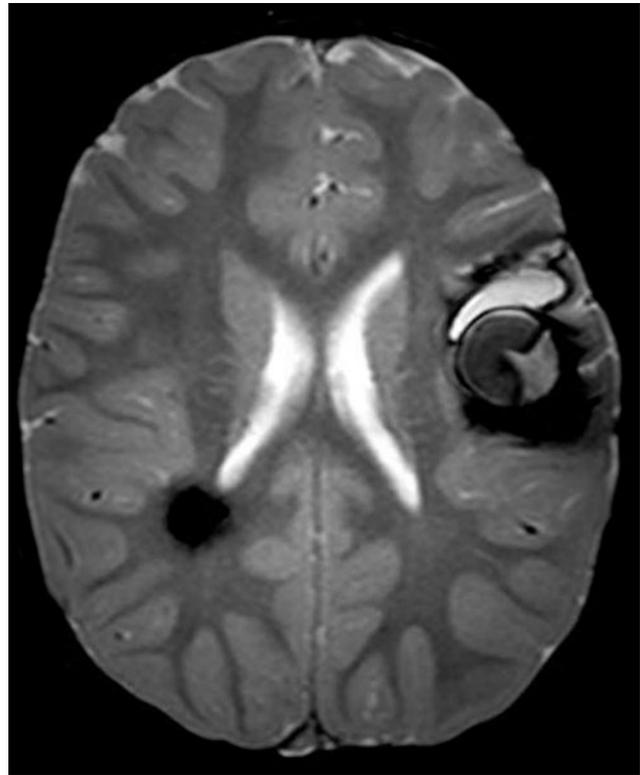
Axial multiplanar gradient-recalled magnetic resonance image showing hemosiderin alterations in the left insular area and right posterior periventricular region. These lesions represent cavernous malformations, and the presence of multiple lesions suggests the diagnosis of familial cerebral cavernous malformation.
